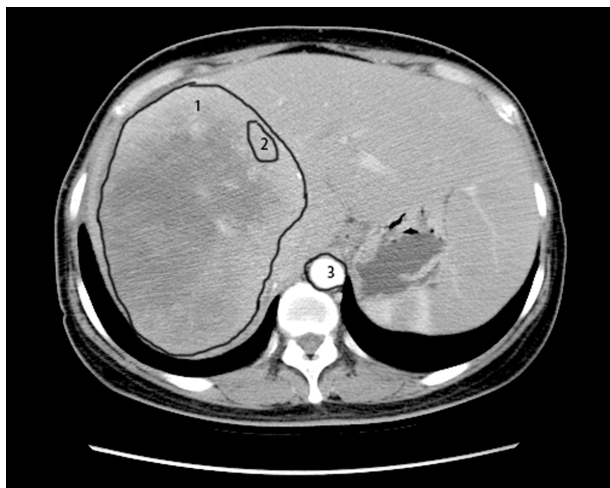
Delineation of target lesions and ROIs. ROI (number 1) was depicted along the contours of the tumor and the average of CT values was calculated as the whole-lesion values. In addition, the ROI (number 2) was generated on the periphery of the tumor; while the ROI (number 3) inside the aorta was depicted to calculate the peri-lesion values. ROI, region of interest; CT, computed tomography.
